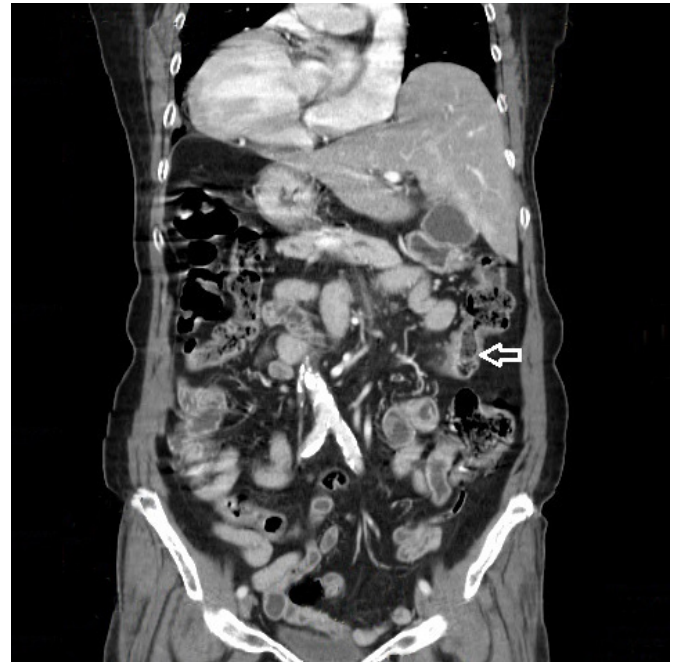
Computed tomography image showing complete inversion of the abdominal viscera and location of the colon cancer (blank arrow).
